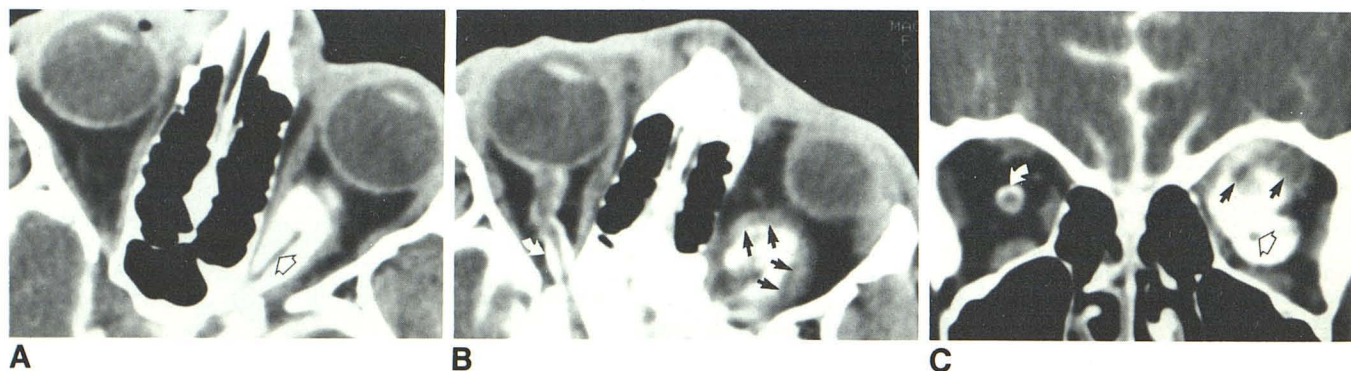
Metrizamide-enhanced axial (A,B) and coronal (C) CT images of opacified left optic nerve sheath cystic mass. Note irregular fibrous capsule of mass (black arrows, B and C), left optic nerve (open arrows, A and C), and opacified normal right optic nerve sheath (curved arrows, B and C).
